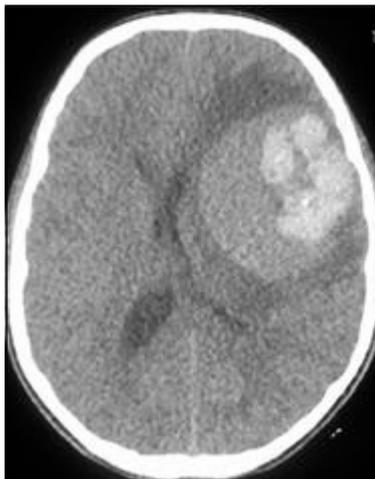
Non-enhanced CT demonstrating hyperdense, heterogenous lesion and areas of hemorrhage at the left fronto-parietal region including millimetric calcifications with lateral ventricle compression and midline shift.
